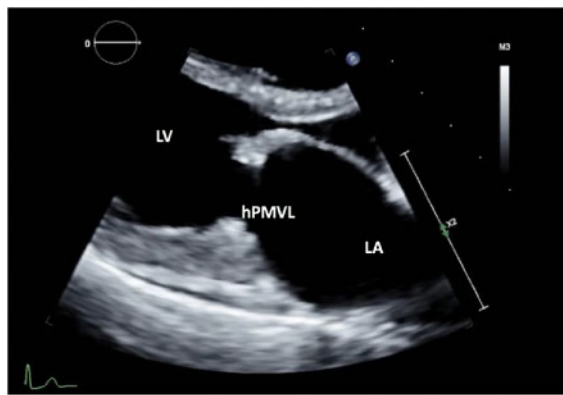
Parasternal long axis demonstrating hypoplastic posterior mitral valve leaflet stump during mitral valve opening. hPMVL, hypoplastic posterior mitral valve leaflet; LA, left atrium; LV, left ventricle.
